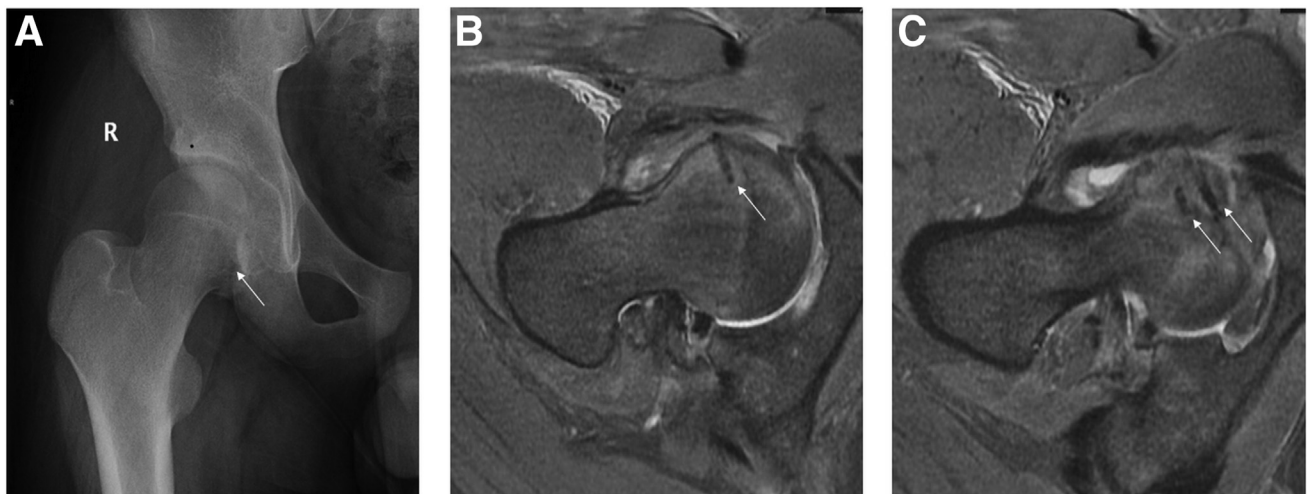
Postoperative radiologic images at 3-month follow-up. Pelvic radiography showing the fracture (white arrow) is reduced and well fixed (A); MRI (osag pd fs) showing the lateral row anchor (white arrow) (B); and MRI (osag pd fs) showing the medial-row anchors and healed fracture line (white arrow) (C). (MRI, magnetic resonance imaging; osag pd fs, oblique sagittal proton density fat-suppression.) (right).
